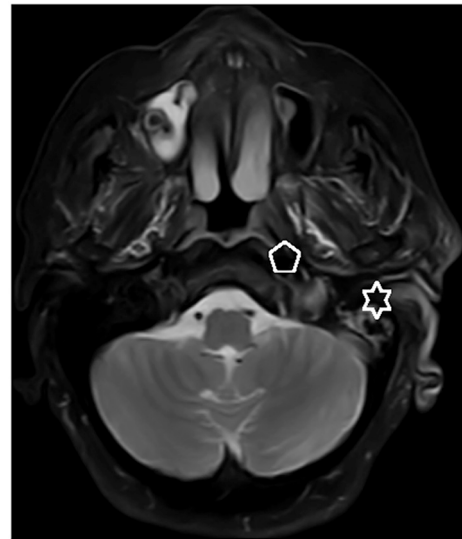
Axial MRI showing swelling and edema of the left ear (star). Soft tissue edema at the base of the skull is also shown (pentagon).
